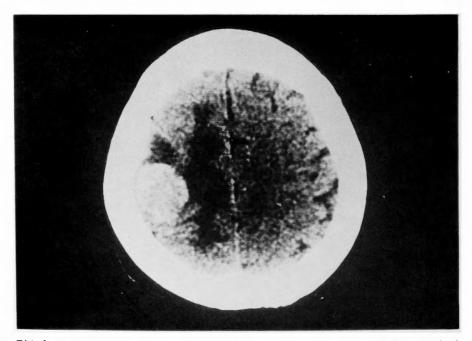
Brain computed tomography shows a high-density mass accompanied by perifocal edema in the right parietal lobe
